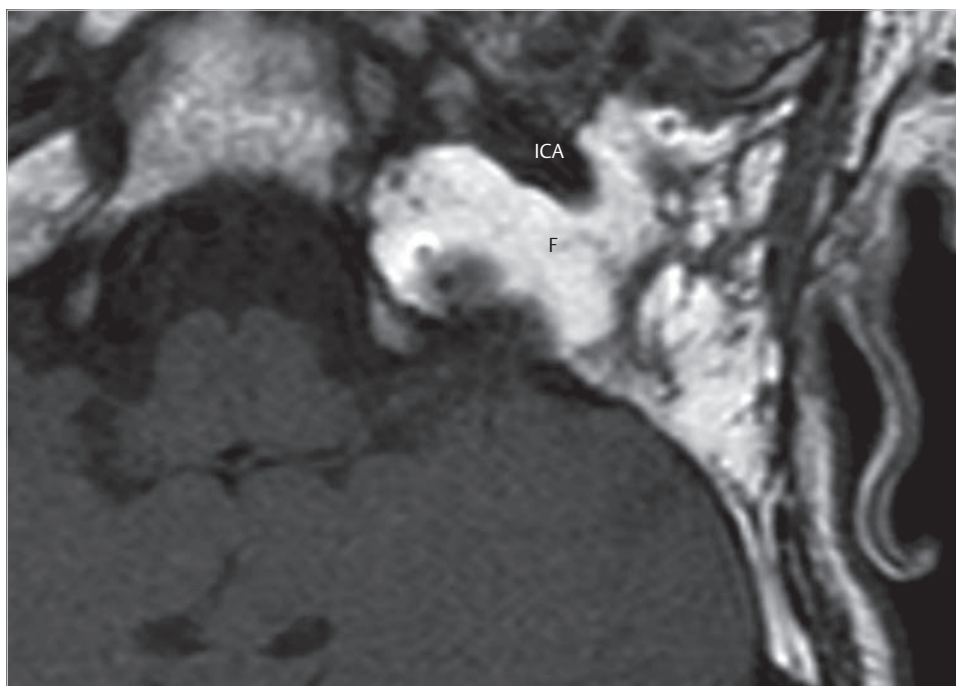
Postoperative MRI shows extensive removal of bone from the petrous apex lesion, and from the area anterior to the carotid artery. ICA, carotid artery; F, abdominal fat.
